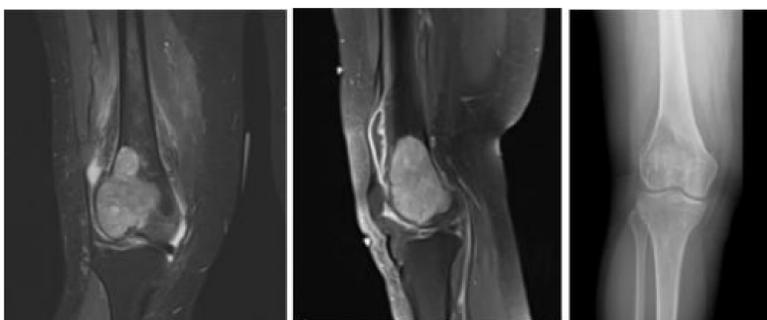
Pre-operative radiographic imaging and MRI scans demonstrating GCT comprising nearly the entire lateral femoral condyle
